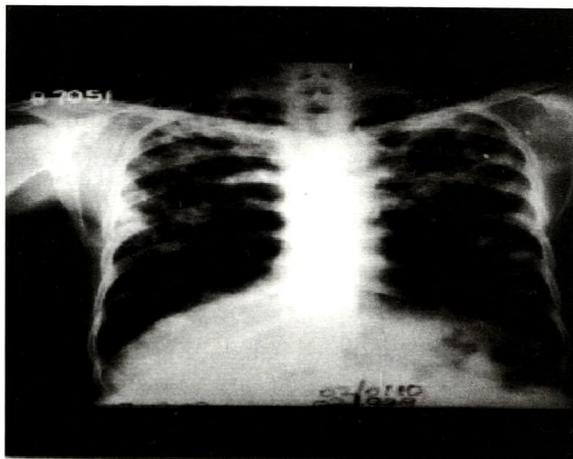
Chest radiograph of the patient showing bilateral patchy nodular opacifications in the upper and middle lung fields with cavitation.
